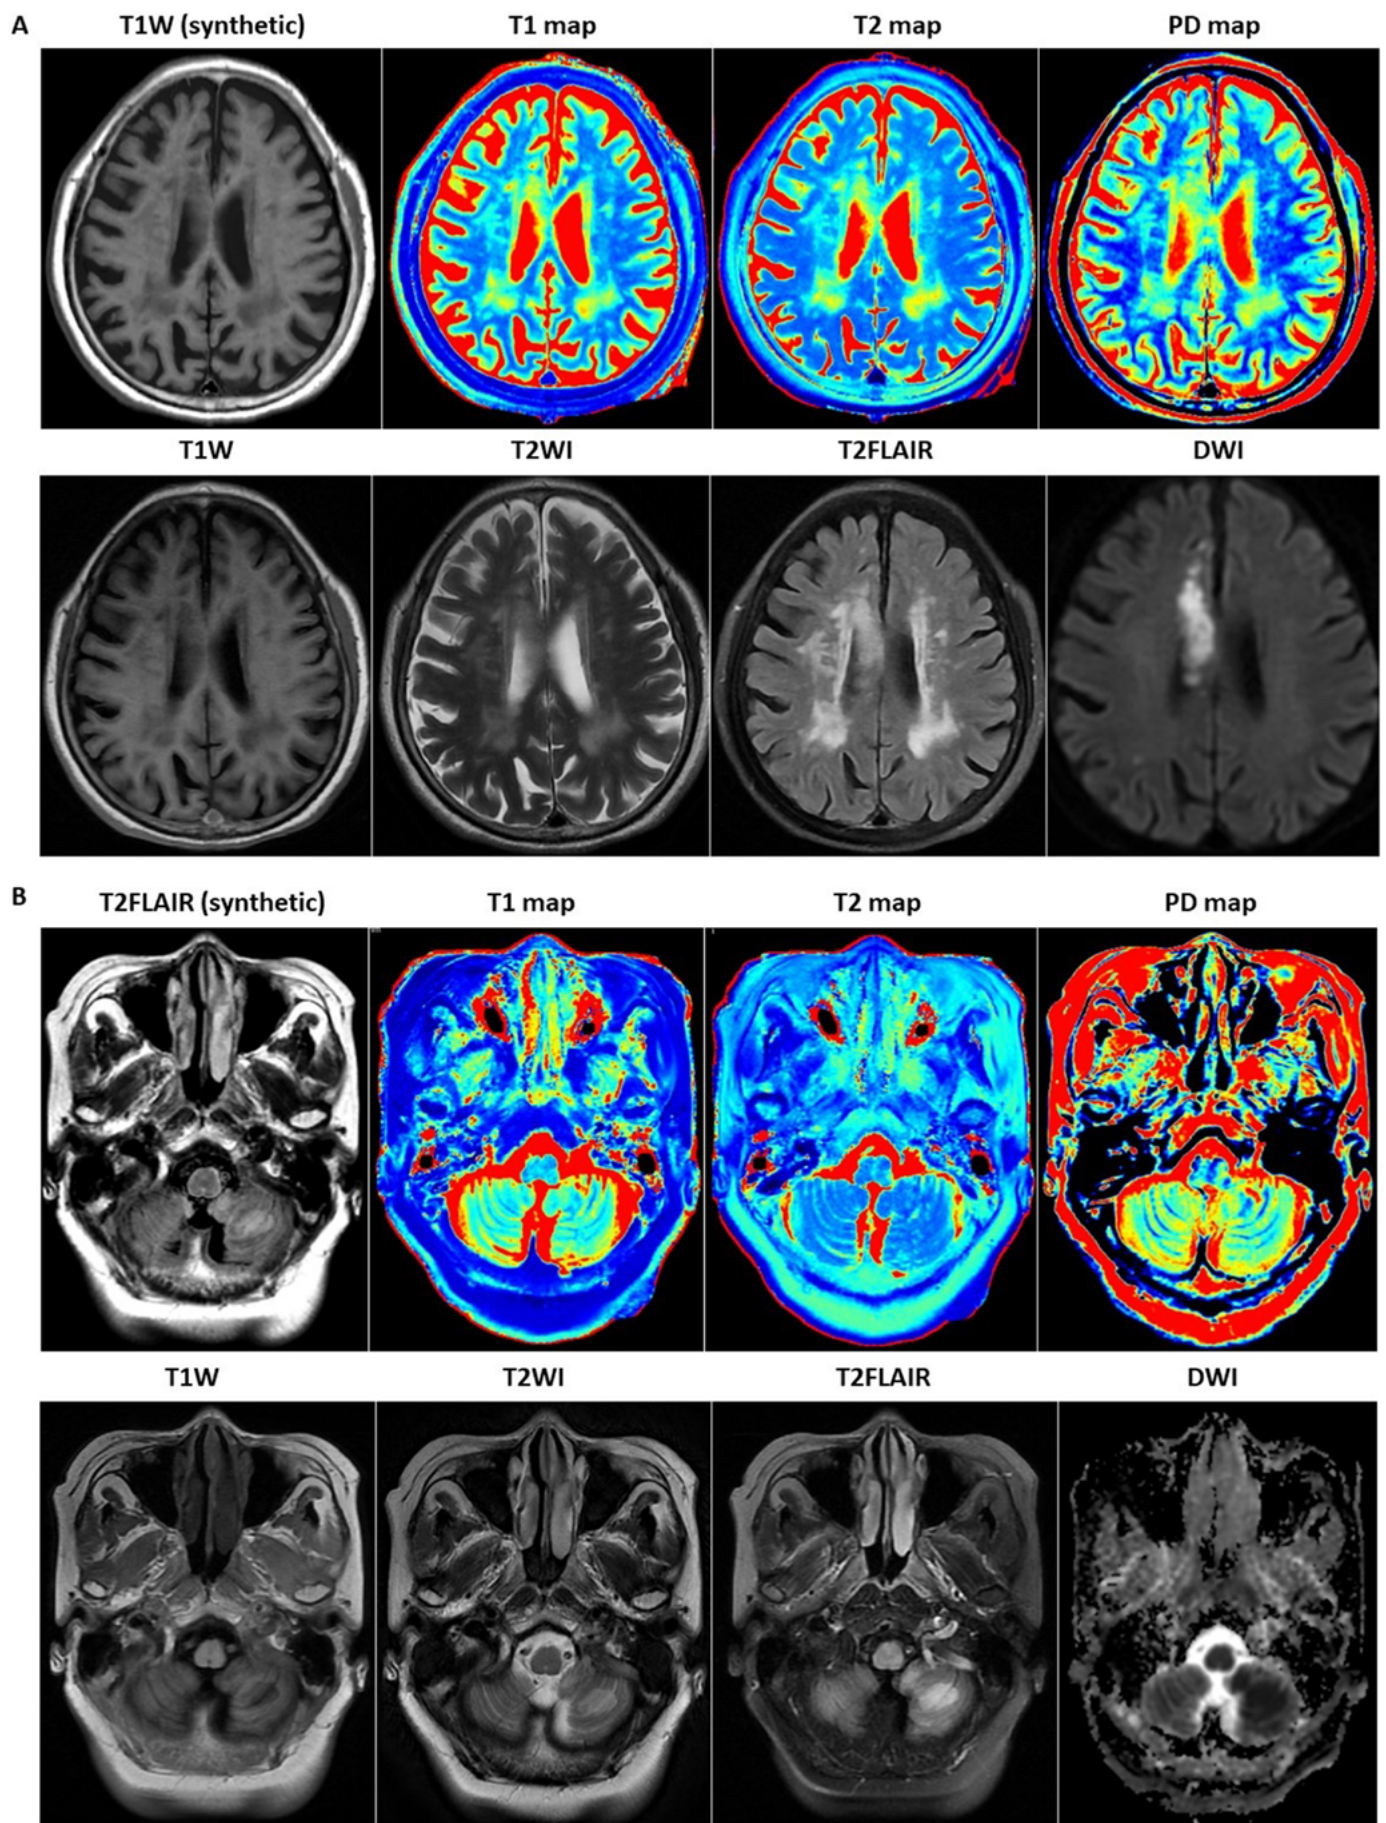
A. Typical images for MAGiC and DCE-MRI of an 84-year-old female stroke patient with acute cerebral infarction in the right frontoparietal lobe. The images are synthetic T1WI, T1 map, T2 map, PD map, T1W, T2W, T2-FLAIR, and DWI; B. Typical images for MAGiC and DCE-MRI of a 63-year-old female stroke patient with multiple acute phase cerebral infarctions in the left posterior medulla oblongata and left cerebellar hemisphere. The images are listed as T2-FLAIR (synthetic), T1map, T2map, PD map, T1W, T2WI, T2-FLAIR, and DWI
